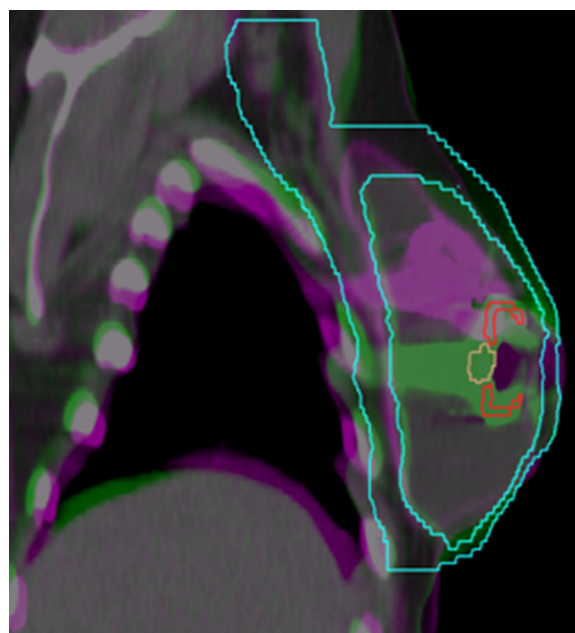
Anatomical position of prepectoral tissue expanders without acellular dermal matrix is not stable. Initial target positioning may be unreproducible, which results with additional delays or unplanned breaks in post-mastectomy radiation therapy due to the need for re-planning. Localization computed tomography image (pink) fused with the reference image (green). Clinical target volume – blue; magnetic metallic port – red and orange. The lack of reproducibility is clearly seen
